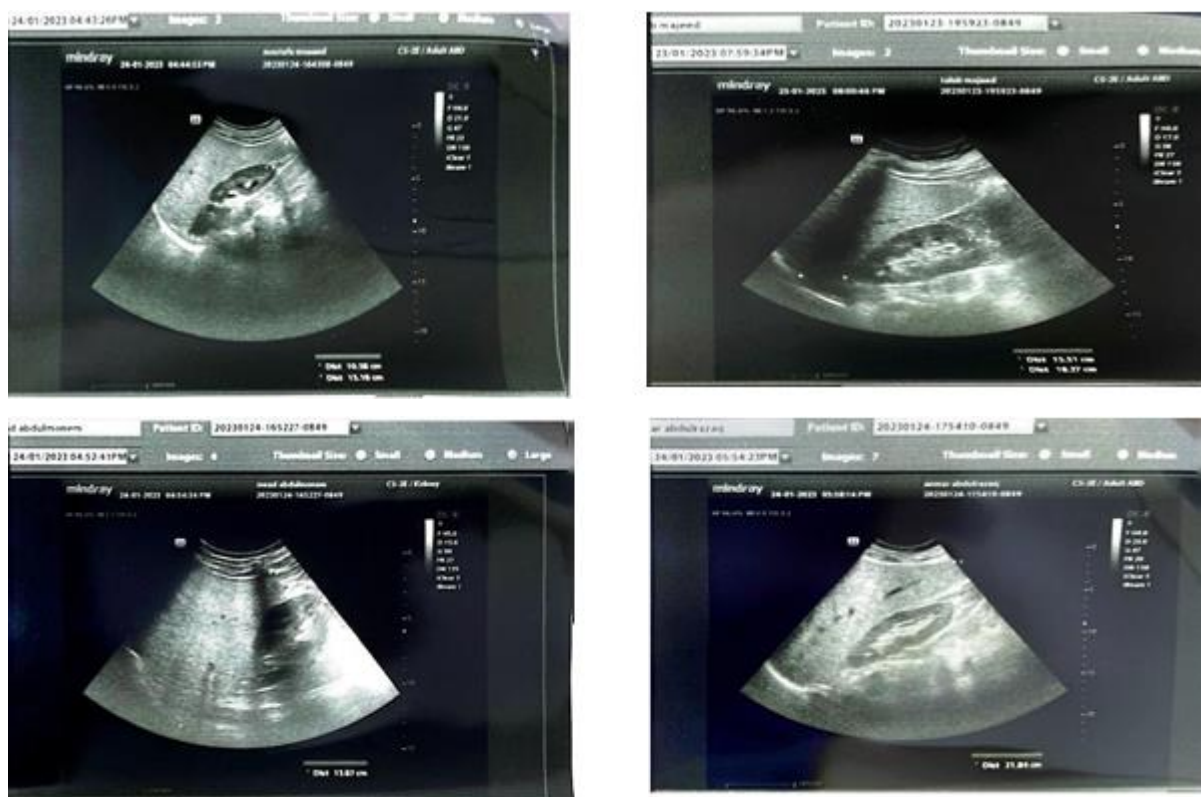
Examples of ultrasound sonar for a different patent with various liver diseases.
